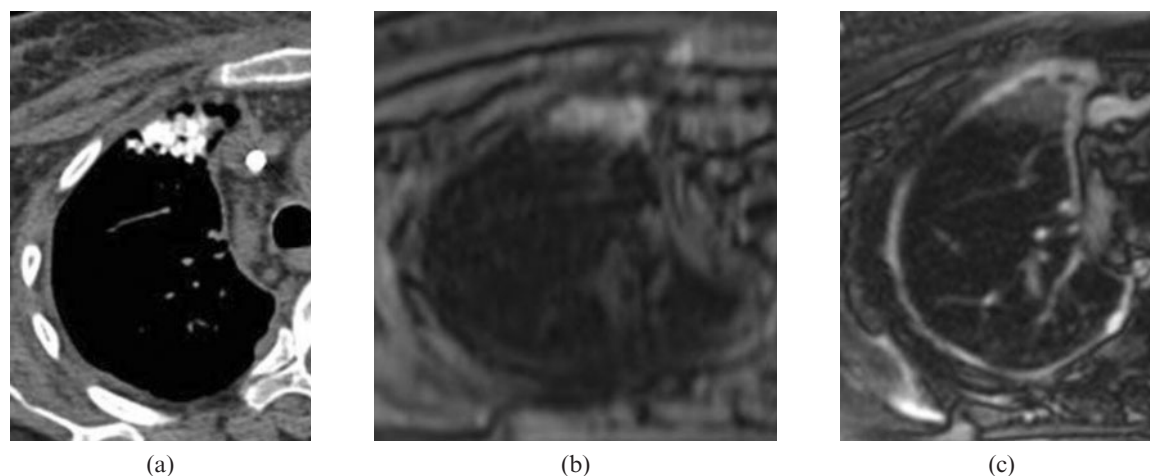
(a) Axial CT scan with mediastinal window showing a consolidation area with calcification in the right upper lobe. (b) Axial T_1 weighted image with fat saturation showing that the lesion has a higher signal intensity than skeletal muscle. (c) Axial T_2 weighted image showing the lesion has a similar signal intensity to skeletal muscle.
